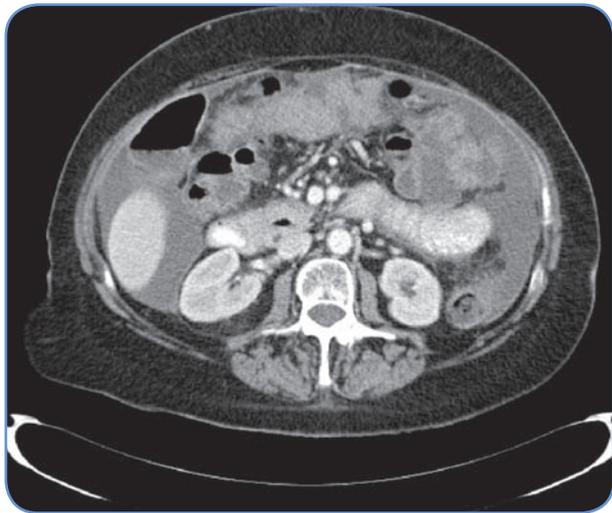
CT scan showing an omental cake and ascites in an ovarian cancer recurrence
